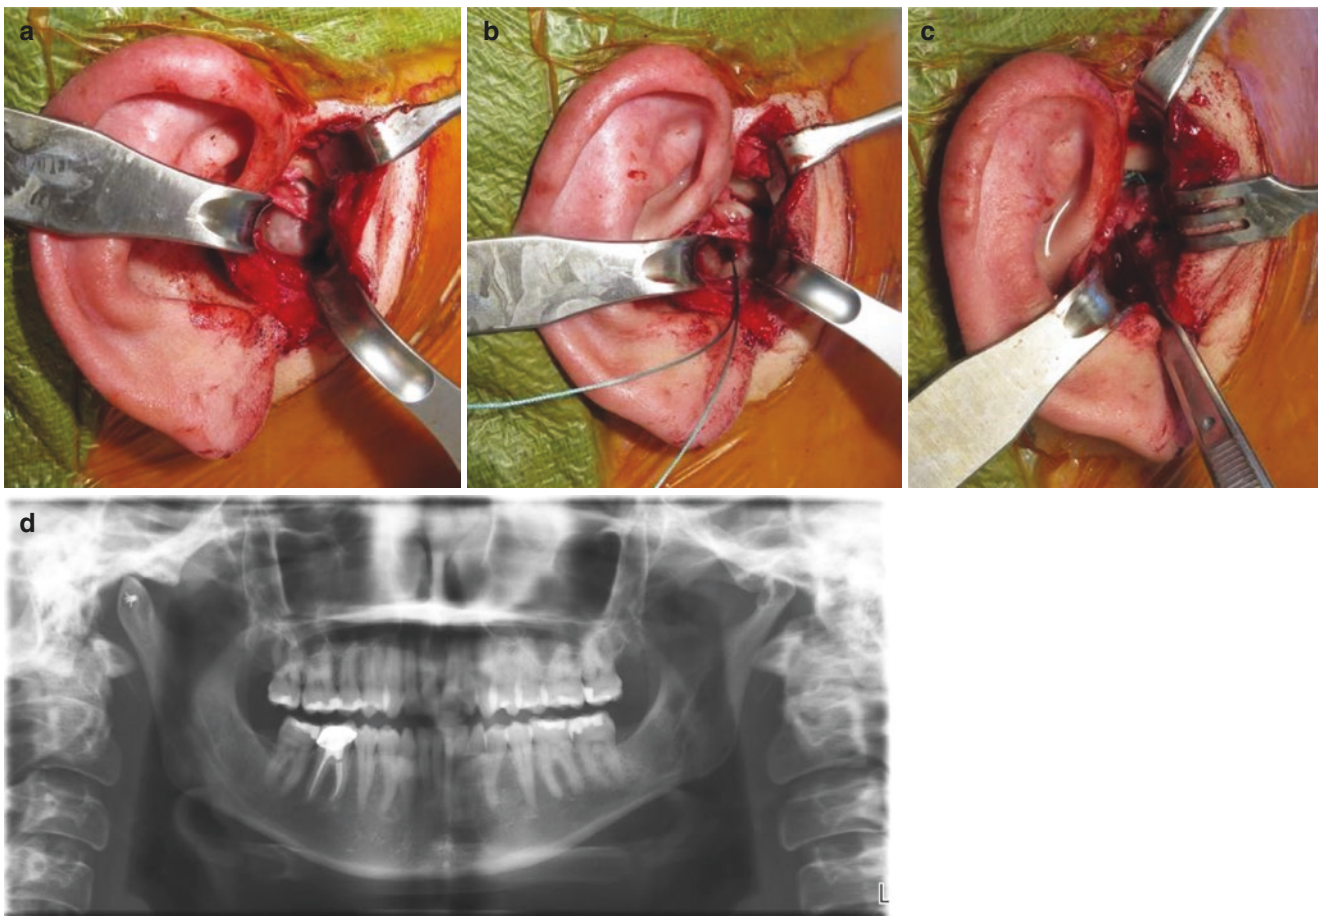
(a) Isolation of the articular disc. (b) Placement of the Mitek anchor (DePuy Synthes, Raynham, Massachusetts). (c) Articular disc repositioned and sutured in place. (d) Post-operative orthopantomogram showing the Mitek anchor within the condylar neck
